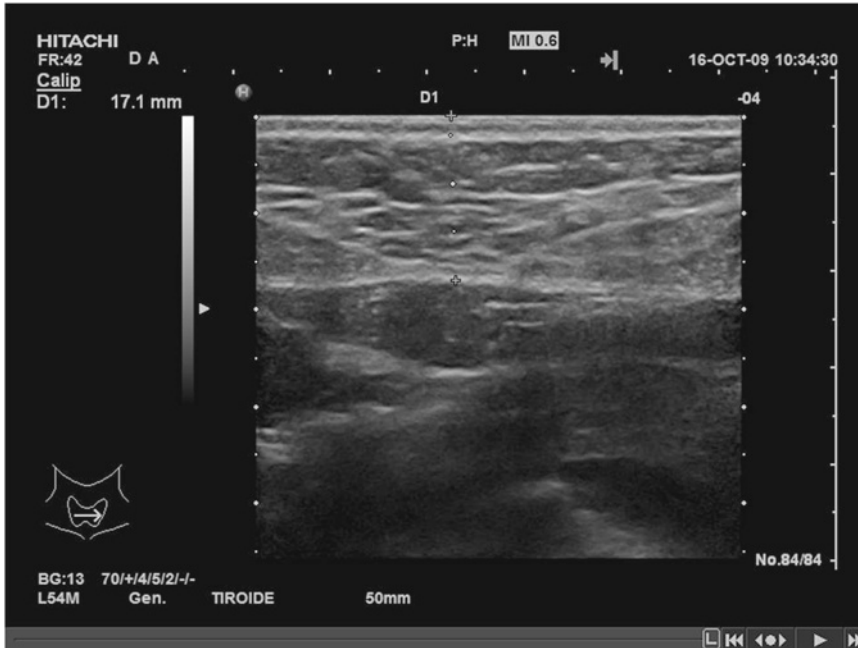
Longitudinal sonogram of the upper abdomen on the xyphoid–umbilical line showing the subcutaneous fat layers. Measurements were taken using electronic calipers placed at the skin–fat and fat–linea alba interfaces
